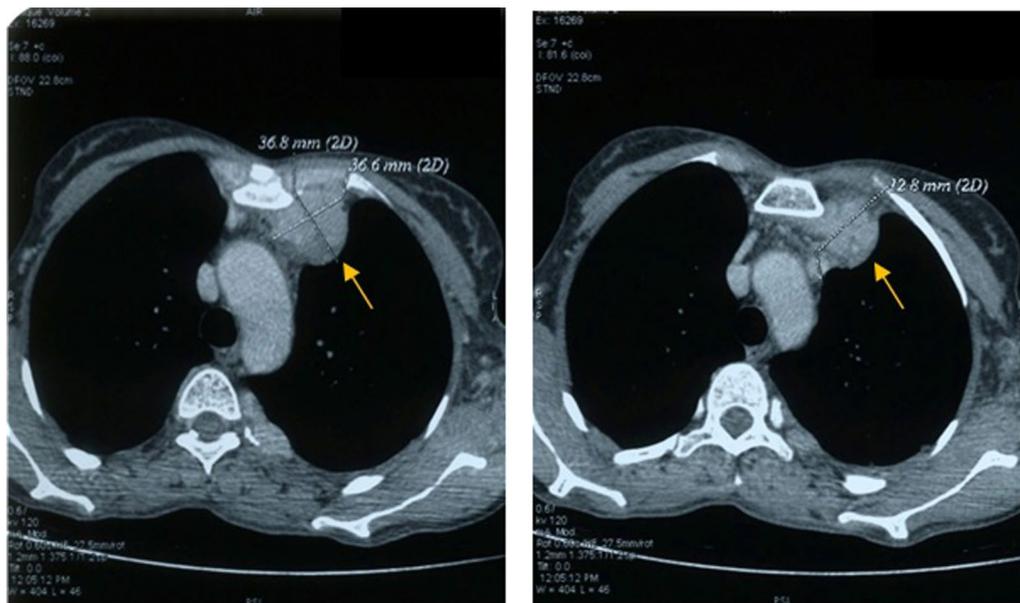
Chest computed tomography scan: mediastinal window. $36 \times 36 \times 50$ mm mass in the right anterior and superior mediastinal region arising from the thymus (yellow arrows)
